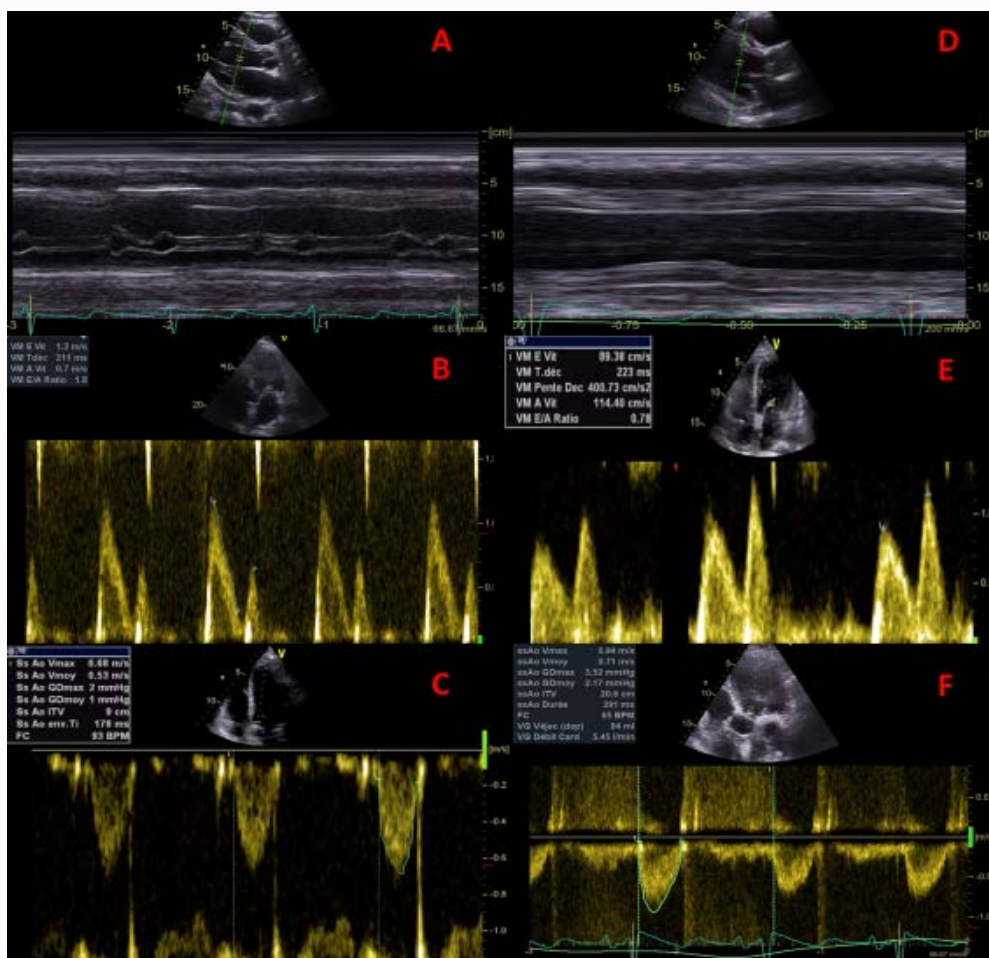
Echocardiographic assessments during cardiogenic shock and recovery. A, D: Left ventricle profile in M-mode, performed in the parasternal long-axis view, during cardiogenic shock (D1) and recovery (D5). B, E: Diastolic mitral inflow in pulsed-wave Doppler performed in apical four-chamber view, with elevated E/A ratio (1.8) during cardiogenic shock (D1) and normalized (0.8) at recovery (D5). C, F: Velocity-time integral of left ventricular outflow tract (VTI LVOT), during cardiogenic shock (VTI LOVT =9 cm at D1) and recovery (VTI LOVT =20 cm at D5).
